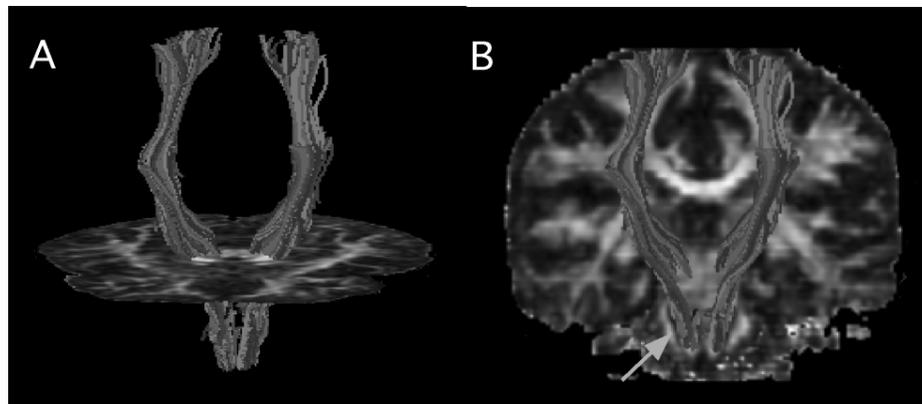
Image of the cortico-spinal path of humans using DTI. These figures show in blue, cortico-spinal fibers going from cortical motor and sensory areas, in their way to brain-stem and spinal cord. a. Descending fibers shown in three dimensions, crossing through an axial structural MRI. b. Same fibers superimposed to a coronal MRI slice. Note how the right and left parts of the pathway get close together at the level of the medulla where they will cross over to the contralateral side. Courtesy of K. Arfanakis. Department of Biomedical Engineering, Illinois Institute of Technology (IIT).
